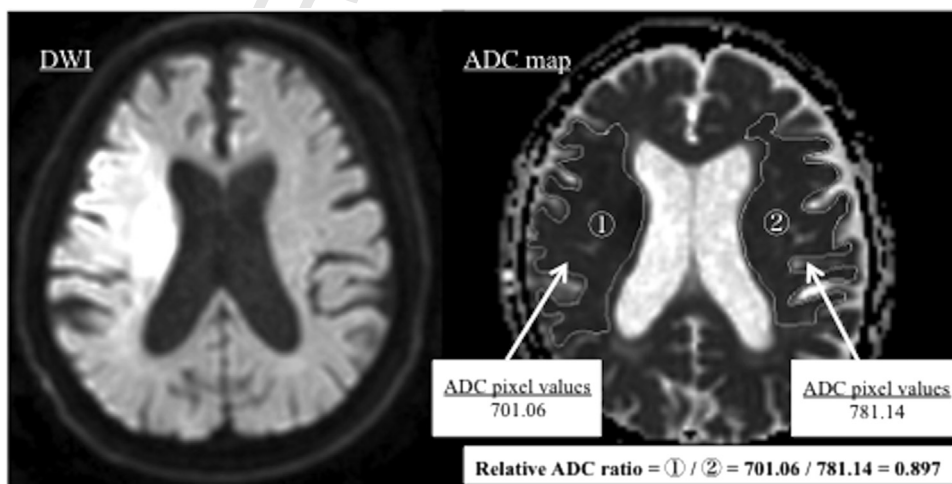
Example of the ratio of apparent diffusion coefficient (ADC) decrease as seen on MRI. Acute lesions of ADC sequences are manually outlined based on the diffusion-weighted imaging (DWI). DWI and ADC are shown on the left and right respectively. The relative ADC ratio was calculated as the ratio of the ADC pixel values within the affected territory (1) to those in the contralateral normal brain regions (2).
